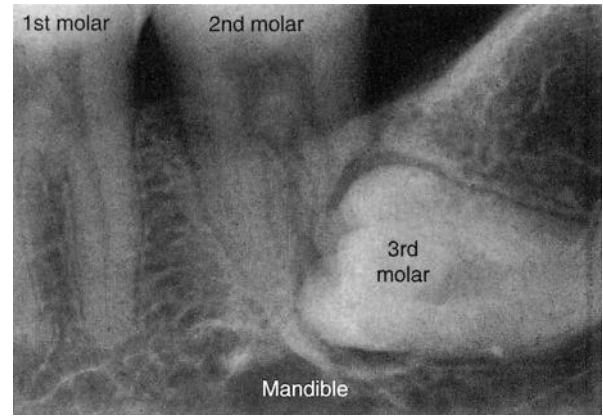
Radiograph of an impacted permanent mandibular third molar. (Courtesy of Margaret J. Fehrenbach, RDH, MS.)
